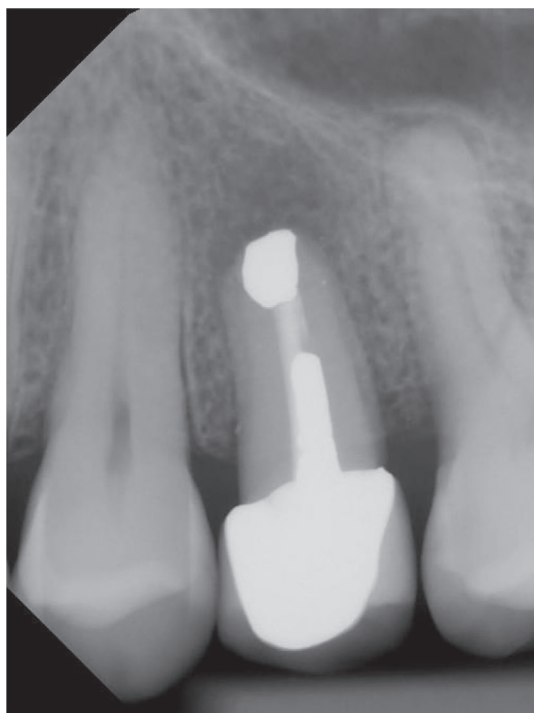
Periapical radiograph showing the apical amalgam seal
